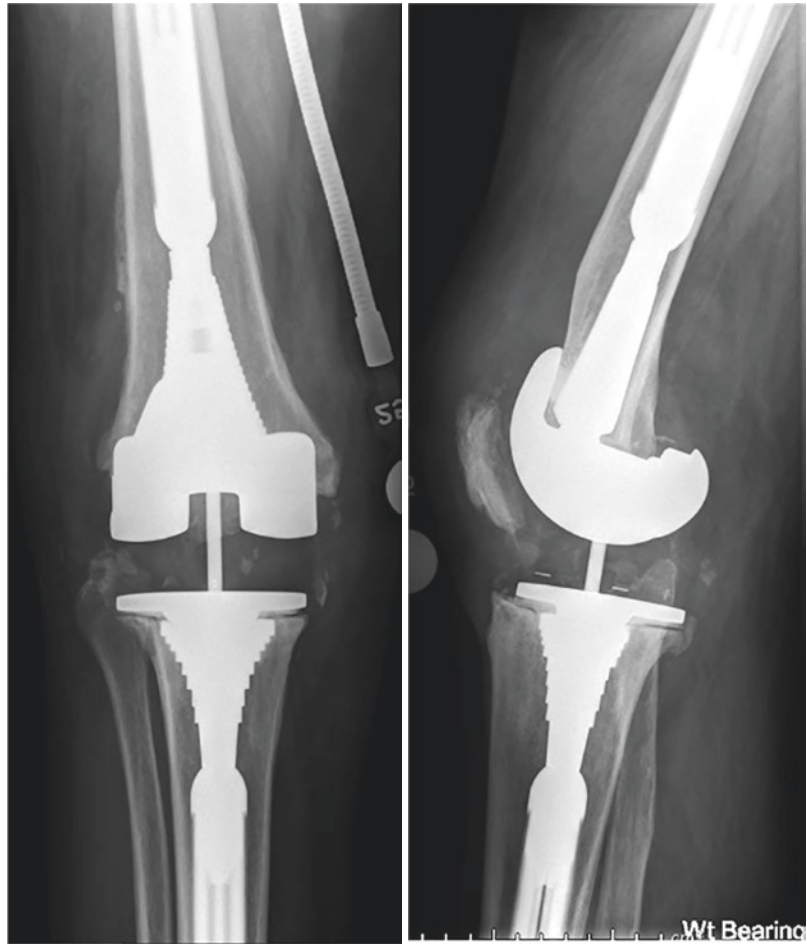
Anteroposterior (AP) and lateral radiographs after reimplantation demonstrating sleeved revision components
